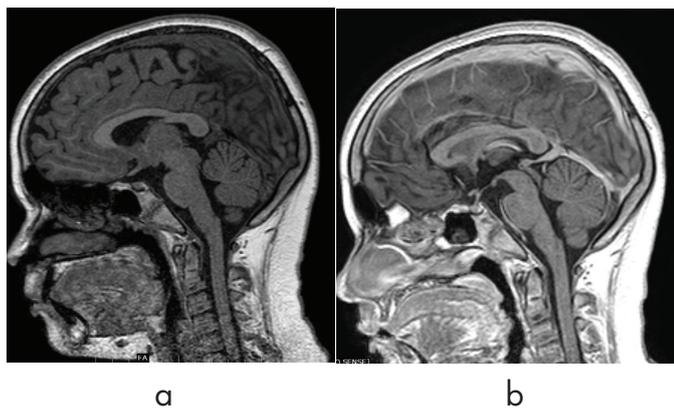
a) T1 weighted axial MRI shows an ill defined, hypointense lesion in the splenium of corpus callosum b) The lesion shows non enhancement on post contrast image
